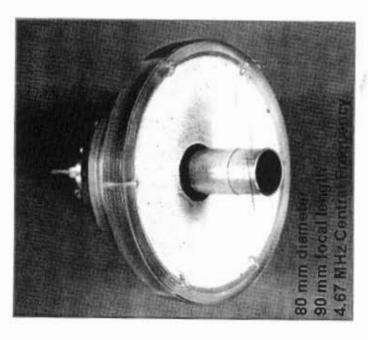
High-intensity focused ultrasound transducer.
